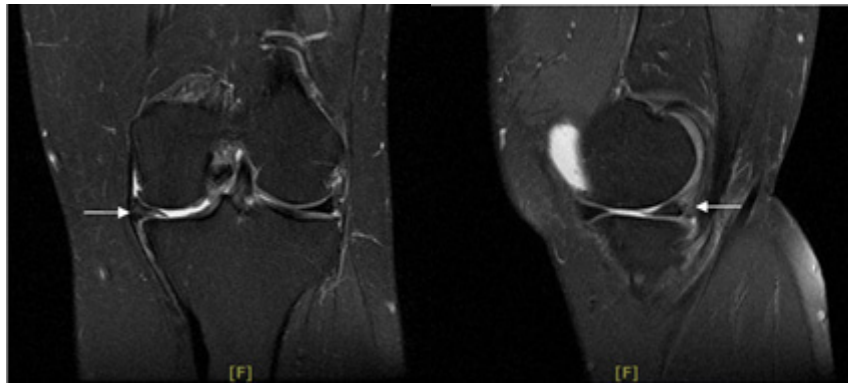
Left knee MRI from case 2(02/04/2020).
